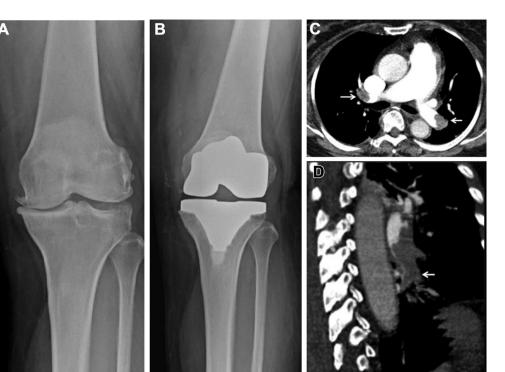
Patient 1, a 65-year-old woman. (A) A plain film radiograph before treatment showed advanced osteoarthritis of the left knee. (B) Plain film radiograph after total replacement of the left knee. (C) Axial computed tomography pulmonary angiogram on the  $3^{rd}$  postoperative day showing pulmonary embolism at the bilateral main pulmonary arteries. (D) Oblique sagittal reformations of computed tomography pulmonary angiogram showing the emboli at the left pulmonary artery extension to the lobar and segmental pulmonary arteries.
